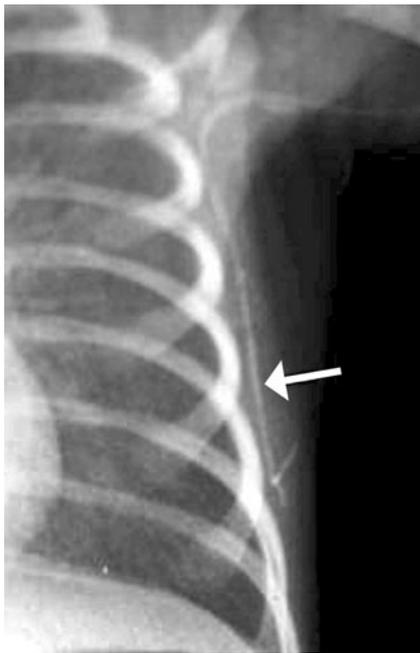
Chest radiograph following oesophageal atresia repair shows a right-sided heart. The central venous catheter forms a large loop within the jugular vein and continues within a left superior vena cava into the coronary sinus (*arrow*)
